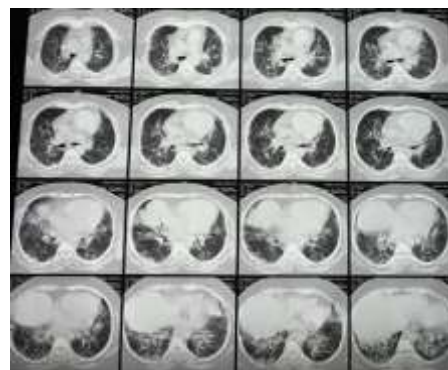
CT Thorax showing; Ground glass opacities, Triple density and early fibrosis features
